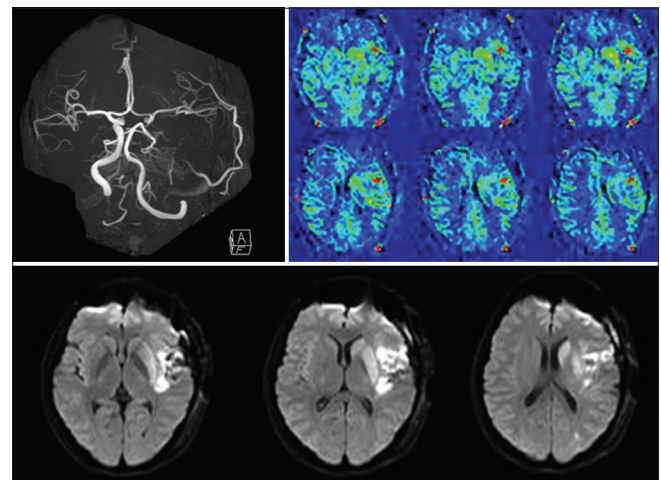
Magnetic resonance imaging studies on postoperative day 1. Intracranial magnetic resonance angiography (upper left) shows complete recanalization of the left middle cerebral artery as well as a robustly patent superficial temporal artery-middle cerebral artery bypass. Arterial spin labeling (upper right) demonstrates slightly increased cerebral blood flow in the left middle cerebral artery area when compared with that on the contralateral side. Diffusion-weighted imaging (lower) shows a high-intensity lesion in the left parasyylvian area and basal ganglia
